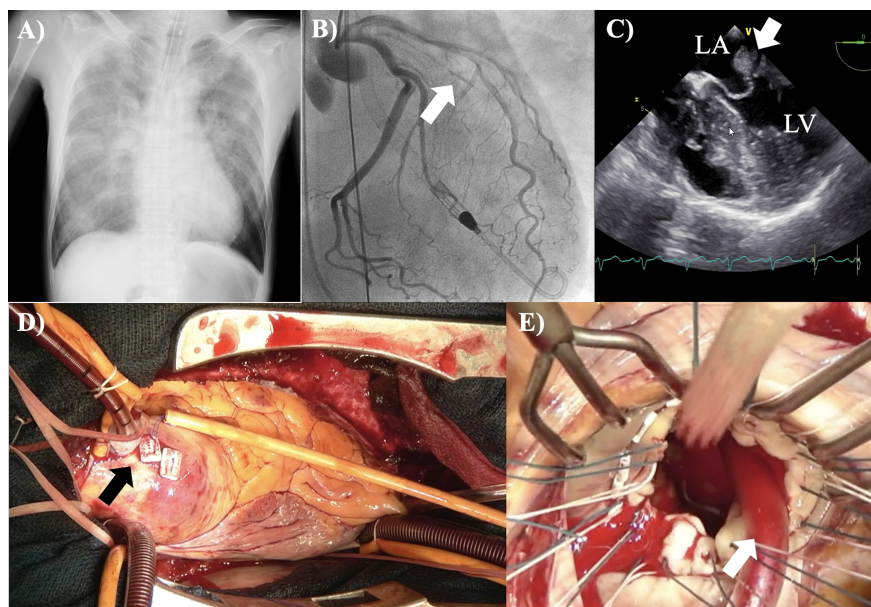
A: Chest X-ray (CXR) on admission revealing significant pulmonary edema (PLE). B: Coronary angiography (CAG) showing occlusion of the high-lateral branch (white arrow). C: Transesophageal echocardiography revealing mitral valve prolapse (MVP) with papillary muscle rupture (white arrow). D, E: Intraoperative findings. LA, left atrium; LV, left ventricle
